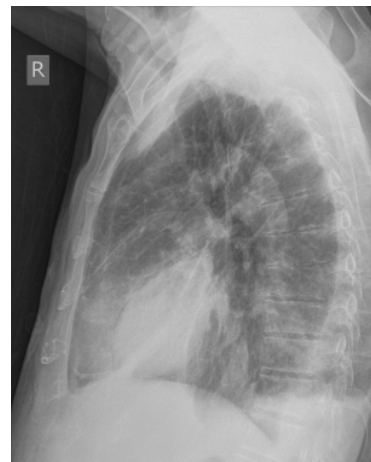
Right lateral chest radiograph.
